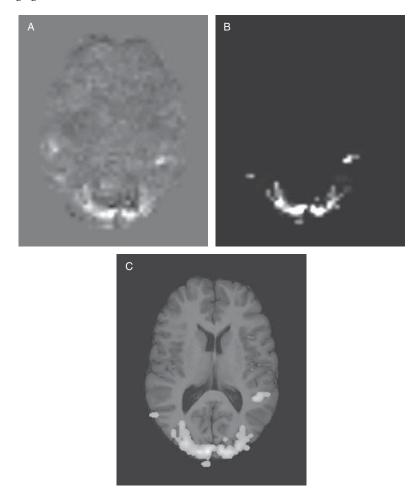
(A) Statistical map obtained from the general linear output. This map is then thresholded at an appropriate p score (B) and is then overlaid on a high-quality MRI scan of the same subject's brain (C).
